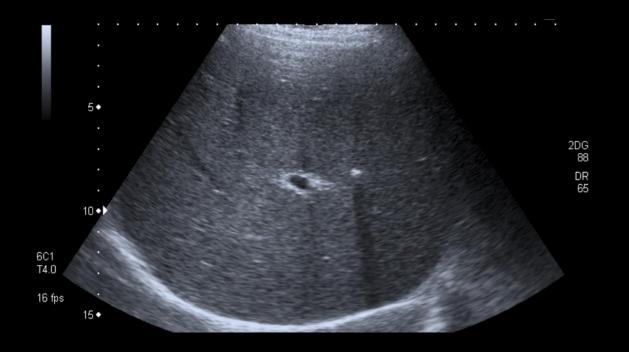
Ultrasound. Calcified Granuloma. A usual finding in granulomatous diseases.
